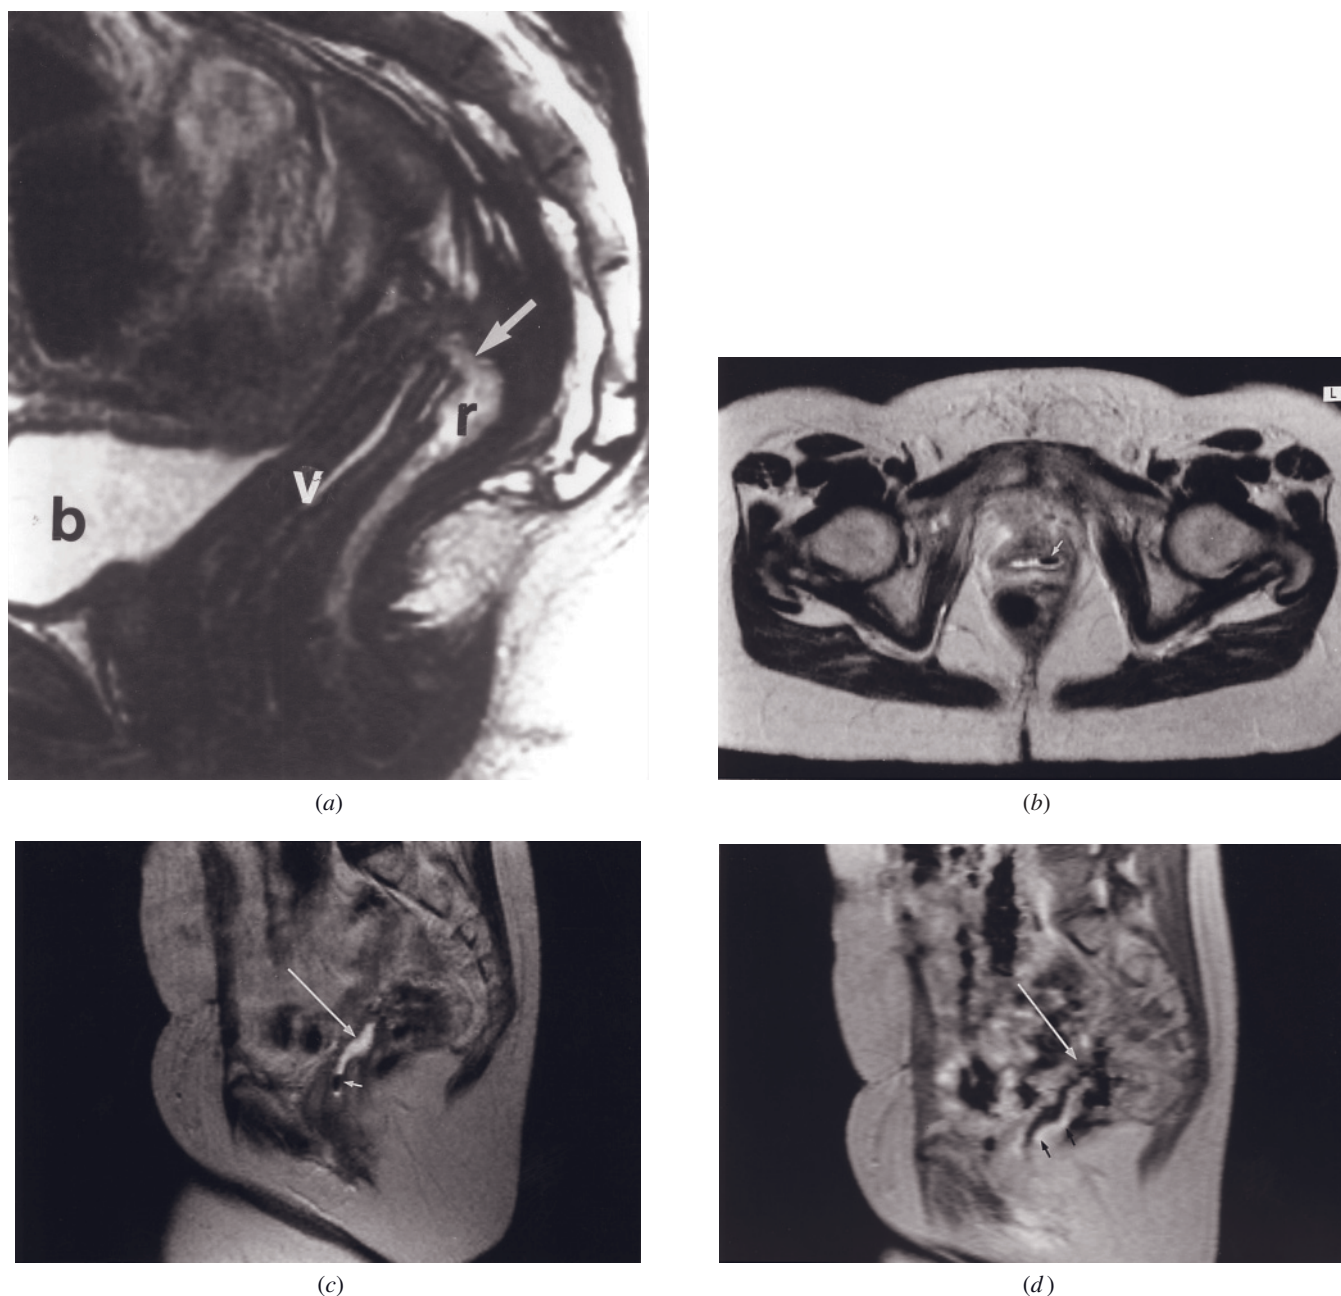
Rectovaginal fistula. Sagittal T2-weighted ETSE image (a) in a 36-year-old woman with history of inflammatory bowel disease and prior subtotal colectomy reveals high-signal-intensity content of the fistula (arrow) that is continuous with the remaining rectal segment (r) and the vagina (v). b, Bladder. Transverse 512-resolution T2-weighted echo-train spin-echo (b), sagittal 512-resolution T2-weighted echo-train spin-echo (c), and sagittal 45-s postgadolinium SGE (d) images in a second patient who is status post hysterectomy for cervical cancer. A signal void focus of air is present in the vagina on T2-weighted images (small arrows, b, c), consistent with a fistulous communication with bowel. The superior aspect of the vagina expands into an abscess cavity (long arrow, c), which is well shown on sagittal-plane images. The gadolinium-enhanced image shows increased enhancement and thickening of the vaginal wall, which is consistent with inflammatory changes (short arrow, d). A fistulous tract is apparent on this sagittal image (long arrow, d) in continuity with adjacent bowel.
